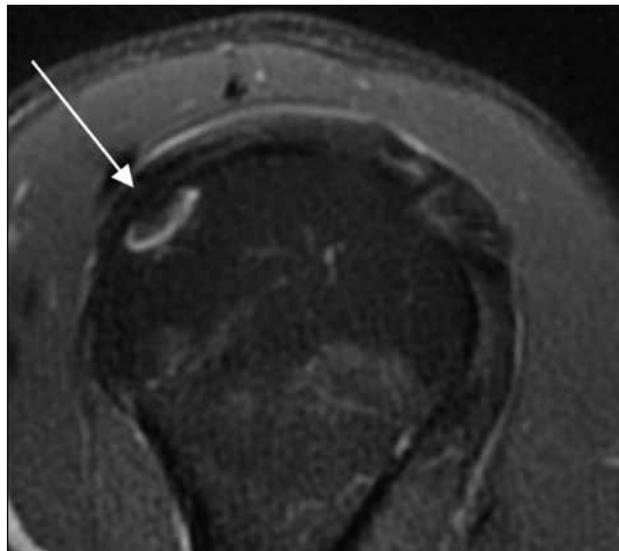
Abbreviation: MRI = magnetic resonance imaging.
